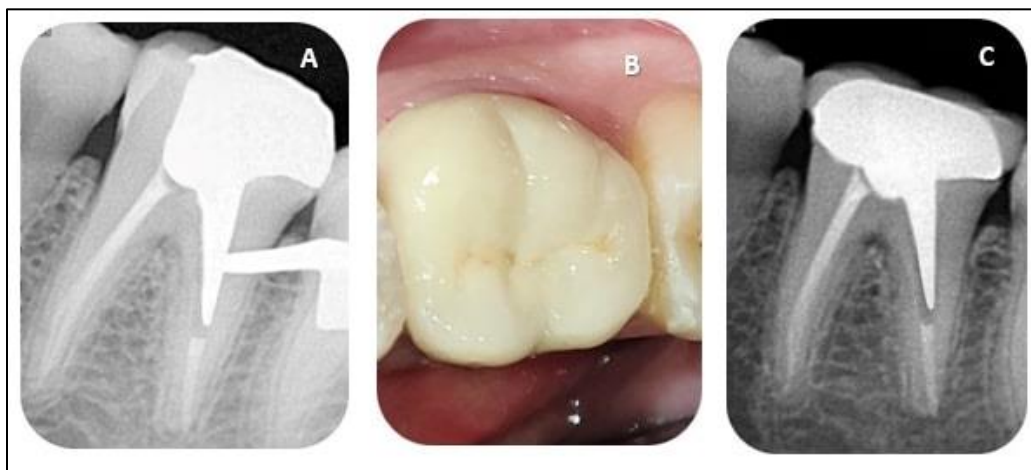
A: Radiograph of cemented Digi post B: post-operative clinical photograph C: post-operative radiograph
